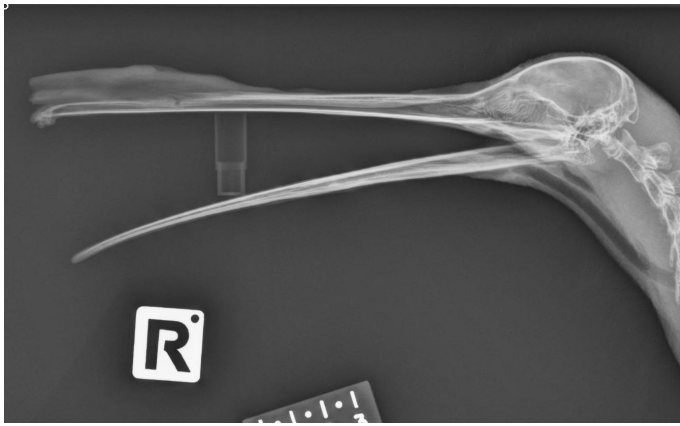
Open mouth lateral radiograph showing a chronic fracture of premaxilla and exuberant keratin growth dorso-rostral to the fracture site.
